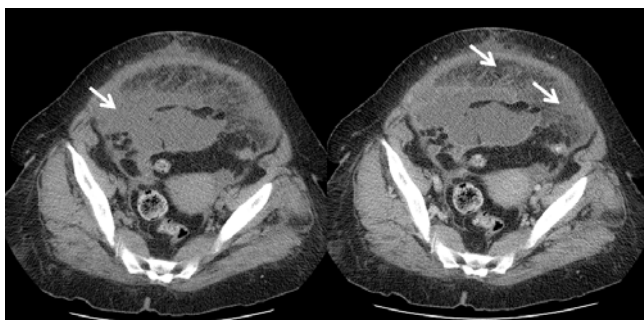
Precontrast and postcontrast axial computed tomography images show intraperitoneal free fluid and ‘omental cake’ appearance.
